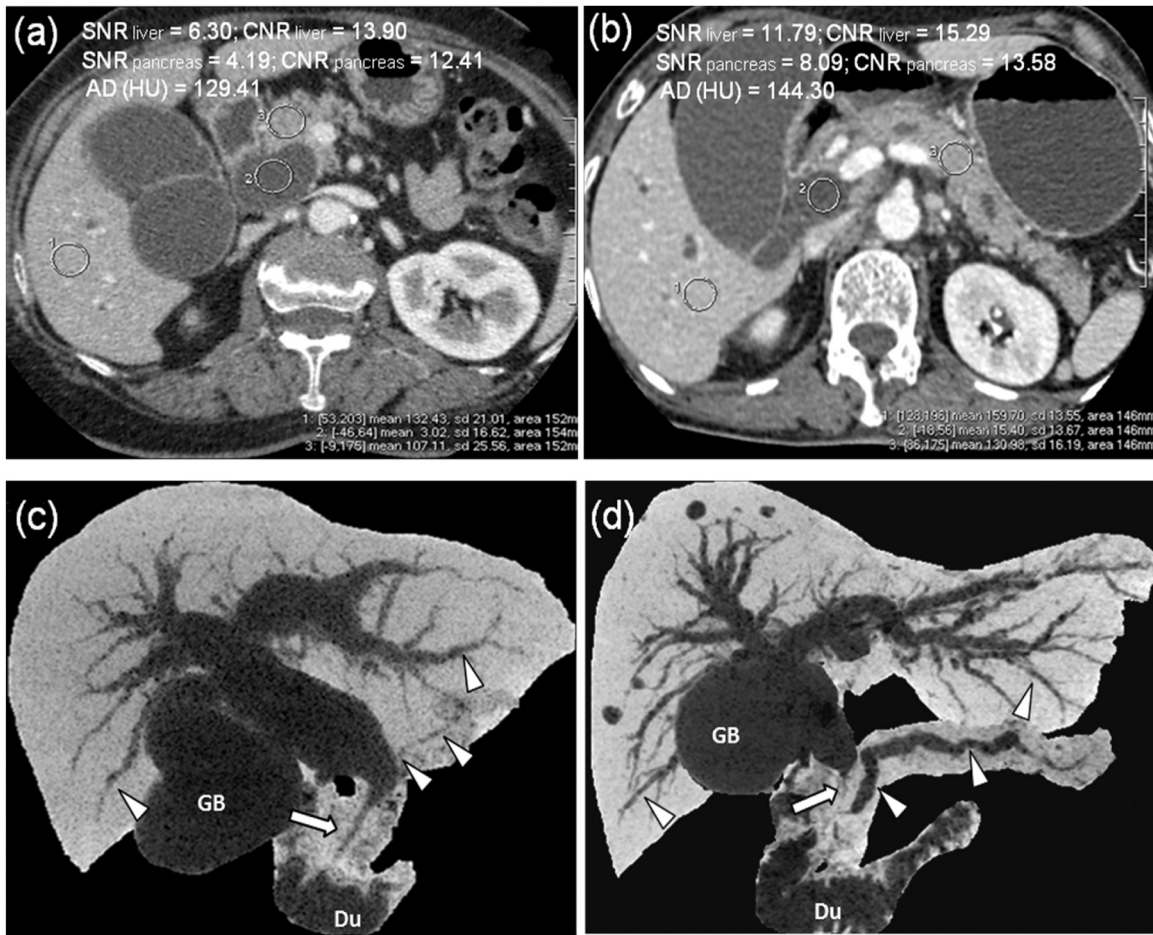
Dilated ducts secondary to distal bile duct carcinomas confirmed by pathology. An objective image quality evaluation of a SECT image (A) in a 68-year-old female with a BMI of 20.39 and DECT image (B) in a 72-year-old female with a BMI of 20.96 on axial images during the portal phase shows that the hepatic and pancreatic parenchyma has a higher CT number and AD but lower noise on DECT than on SECT. Both the SNR and CNR on DECT were also higher than those on SECT in the two patients. Subjective evaluation of 3D nCTCP with MinIP image quality from SECT (C) and DECT (D) shows abrupt strictures of the distal common bile duct on both 3D nCTCPs (arrows), however, an almost imperceptible image noise, sharper intrahepatic and pancreatic ductal margins (arrowheads), and better overall image quality on DECT vs SECT (all grades of 5 vs 4). Du, duodenum; GB, gallbladder.
